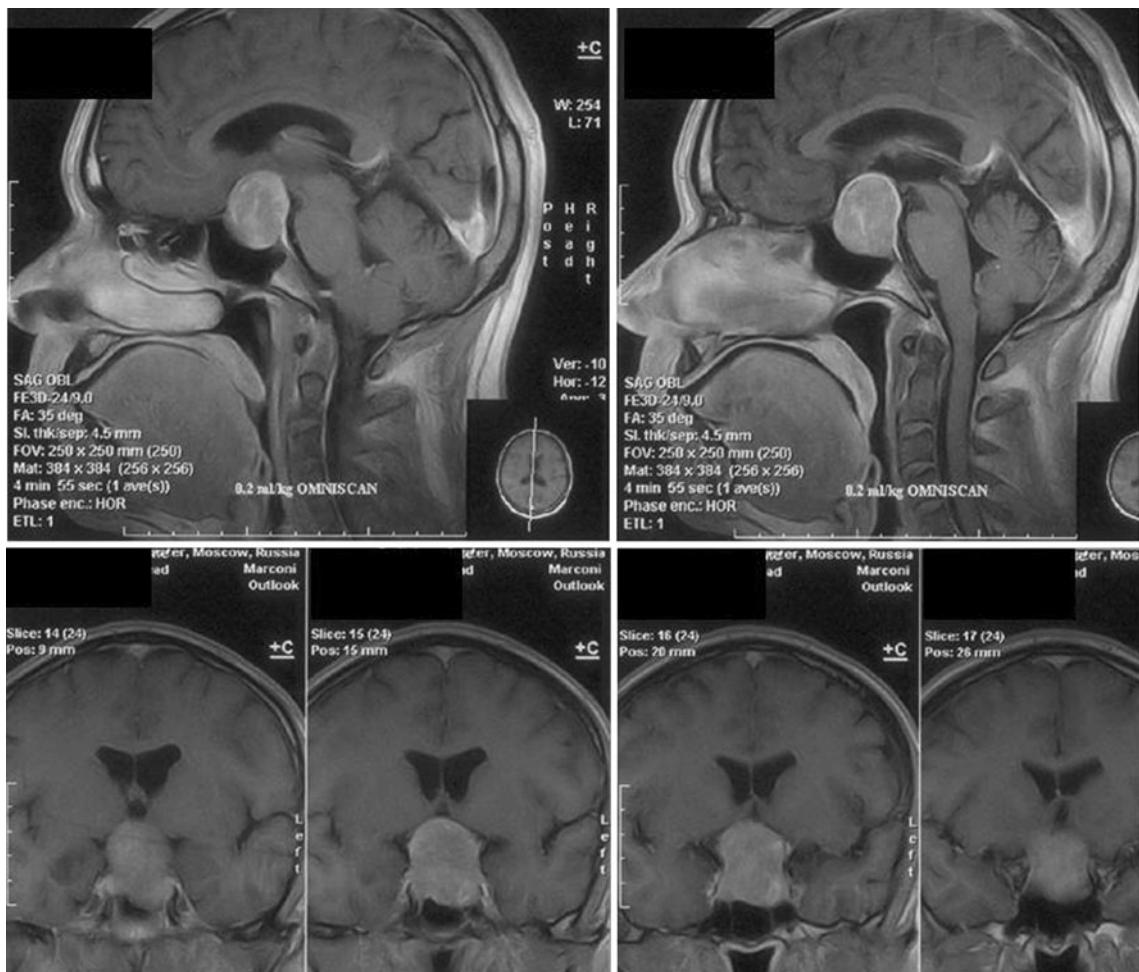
MRI before operation (first case)
